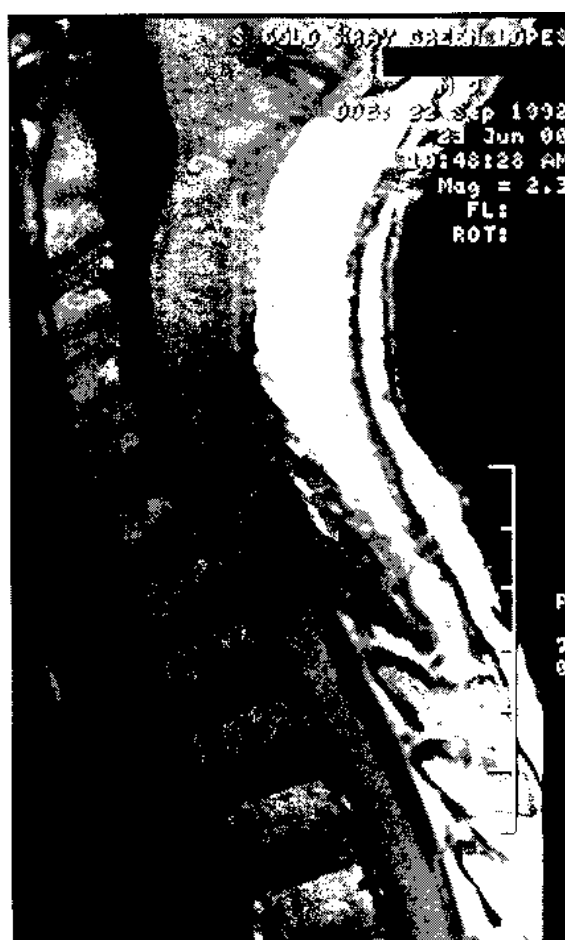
Case 6 at language testing (6 months post treatment): Sagittal T1 weighted MRI scan demonstrating post-operative changes in posterior right aspect of upper cervical spine. Expansion and irregular enhancement within the cervical cord from medulla through to approximately T1 level consistent with primary cervical cord astrocytoma.
